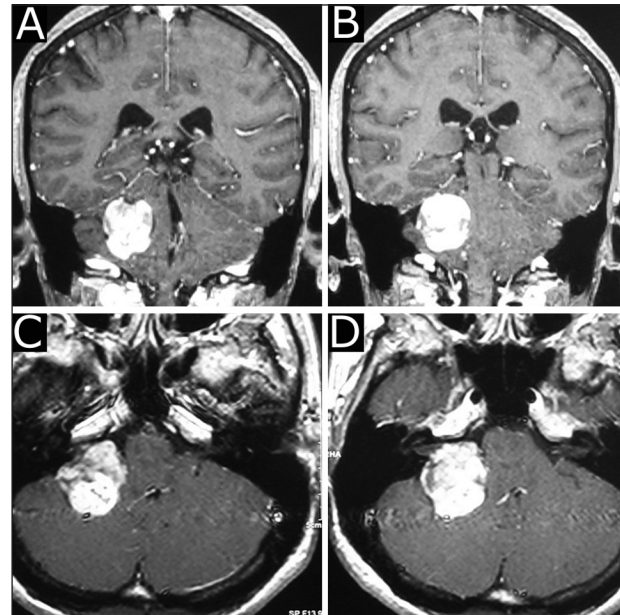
(A–D) Preoperative MR coronal and axial T1-weighted images with Gadolinium demonstrate a globular, uniformly enhancing lesion in the cerebellopontine angle, distorting the brainstem and fourth ventricle. Small extension into the porus acusticus is seen.
